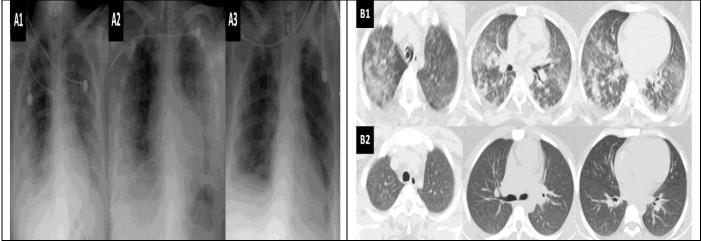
5th patient in the table: Bilateral air space alveolar consolidation (non-cardiogenic pulmonary edema) and daily (1st,2nd and 3th) response to treatment were seen in figure 2A. HRCT images (bilateral alveolar consolidations) at hospital admission and response to treatment were seen in figure 2B.
